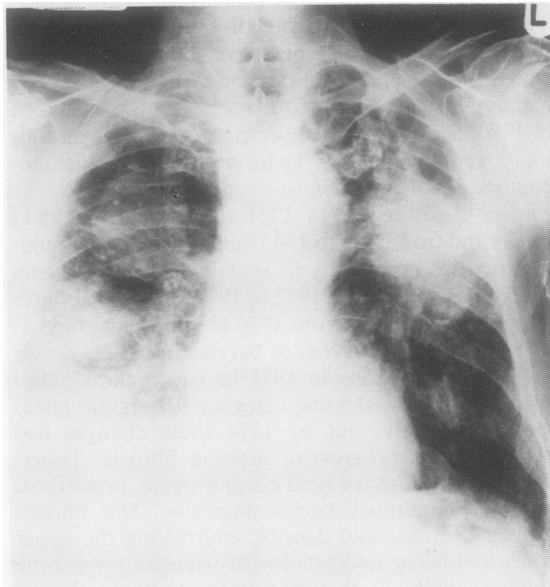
Posteroanterior radiograph of patient 1 showing bilateral massive fibrosis with associated bullous emphysema; pleural thickening is present in the right lower zone.
